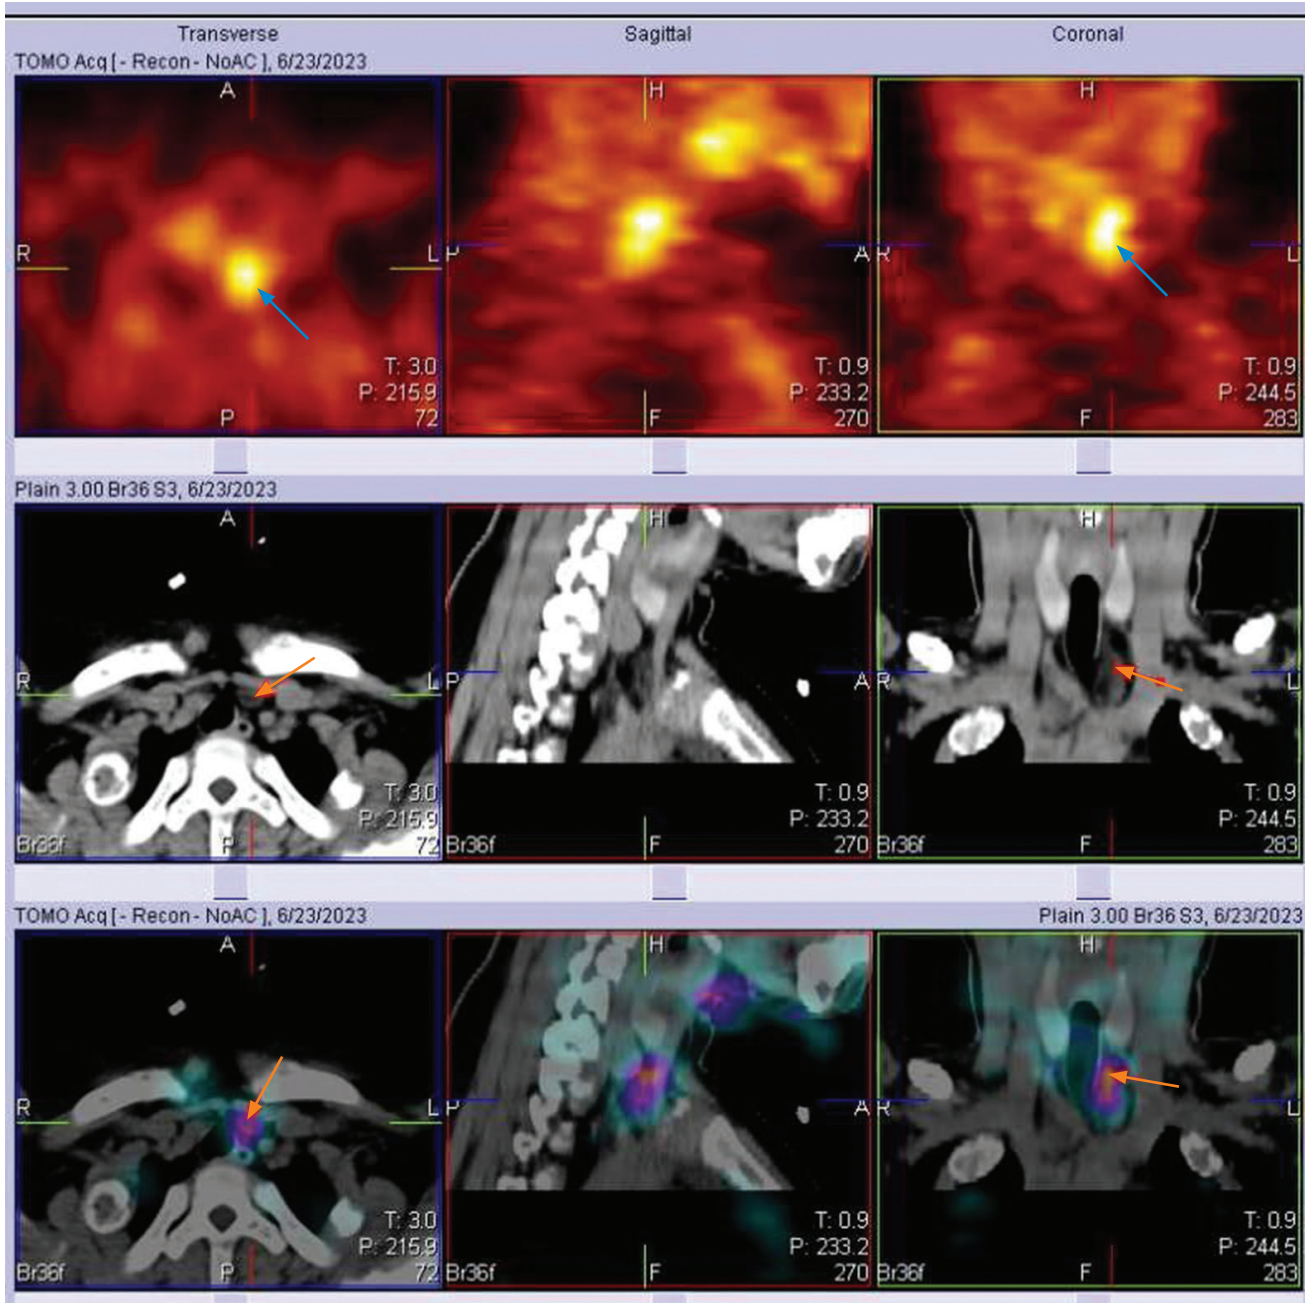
Technetium (^{99m}Tc) tetrofosmin and SPECT/CT scan showing ^{99m}tracer accumulation in the region of the left inferior parathyroid gland suggestive of left inferior parathyroid adenoma.
